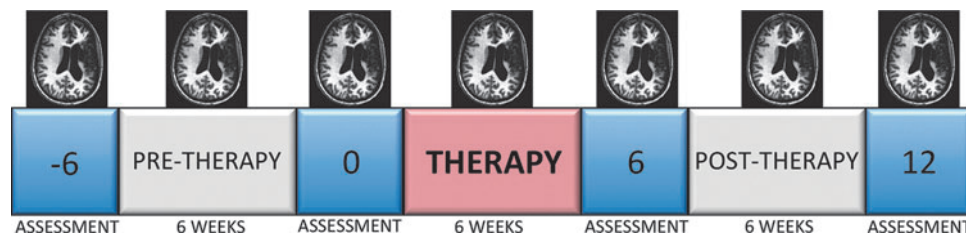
Study design. Total study duration was 18 weeks. Six week baseline preceded a 6 week course of therapy, which was followed by a 6 week maintenance interval. Numbers indicate weeks at which behavioral assessment was performed. Magnetic resonance images indicate time points at which neuroimaging was acquired. Color images available online at www.liebertpub.com/brain
